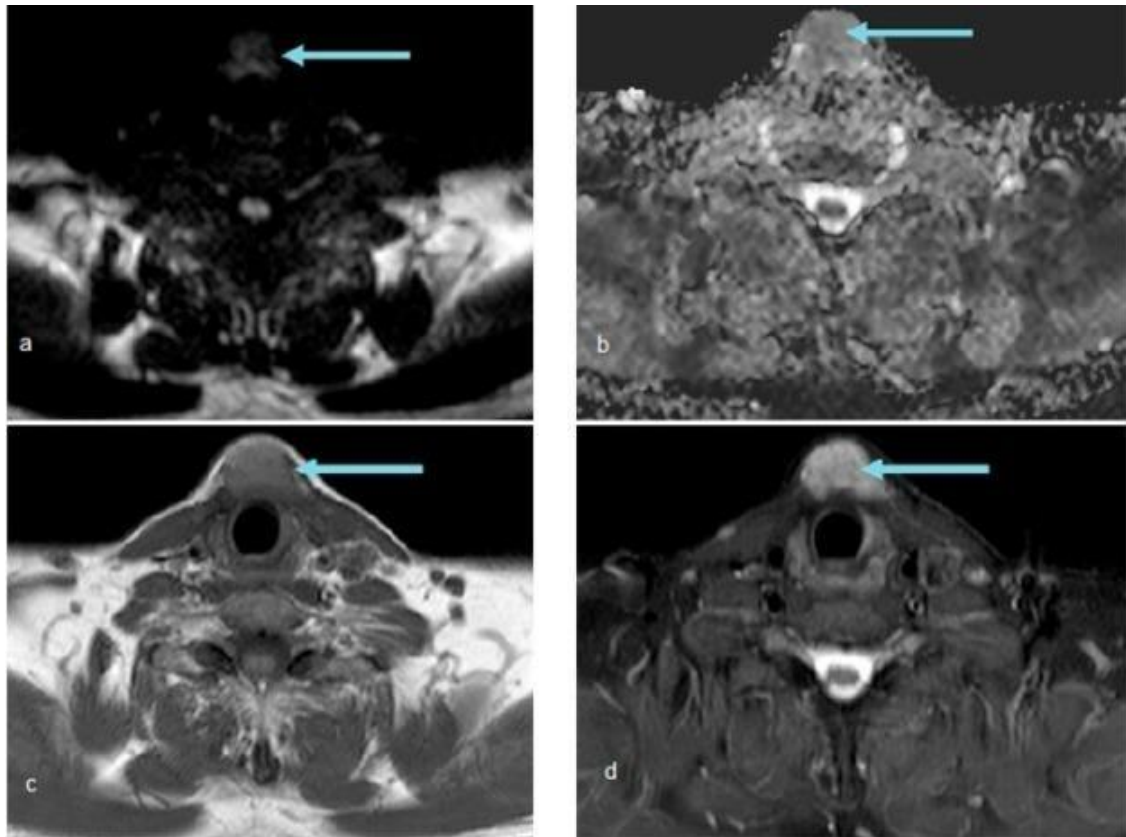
(a–d) MRI images (a) Axial DWI (b) Axial ADC map (c) Axial T1WI (d) Axial STIR. These images show recurrent thyroid nodule (arrows) demonstrating low T1 and high STIR signal intensity with restricted diffusion seen as intermediate signal intensity in the DWI and low signal intensity in the ADC map with a mean ADC value reading $1 \times 10^{-3} \text{ mm}^2/\text{s}$.⁵⁹
